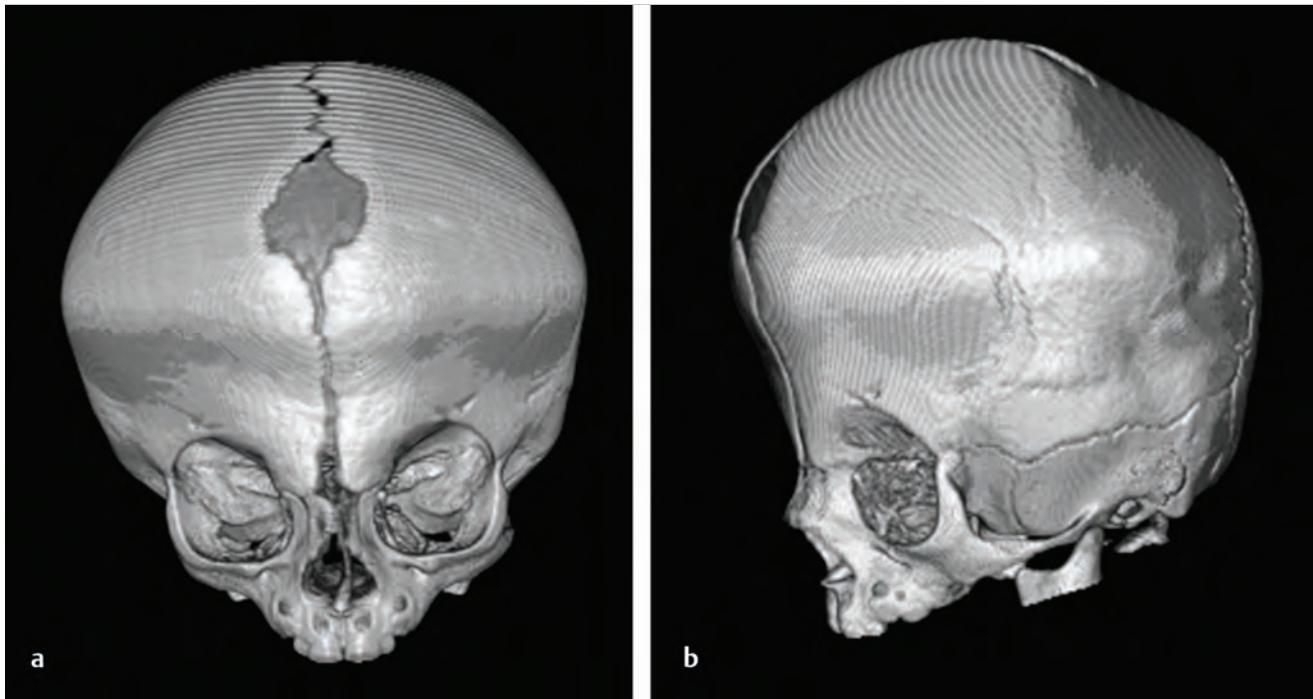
CT images of bilateral coronal synostosis. (a) Anteroposterior view. (b) Lateral view.
